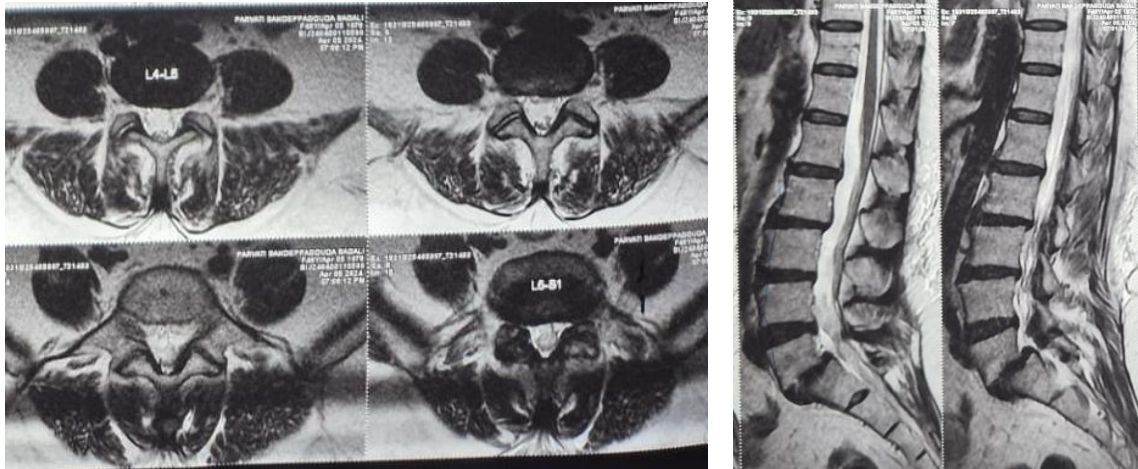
67 – Pre op MRI showing L5-S1 listhesis with pseudo-Disc bulge.
